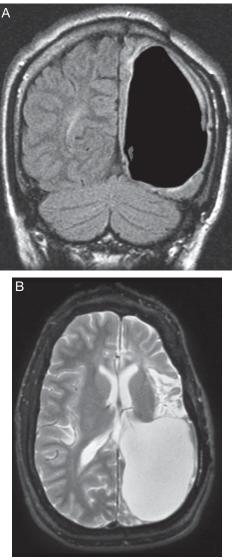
Porencephaly on Magnetic Resonance Imaging.
